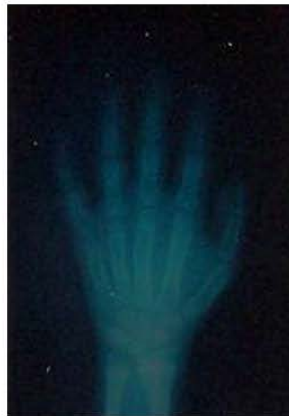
Hand-wrist radiography of a nine-year-old female patient
